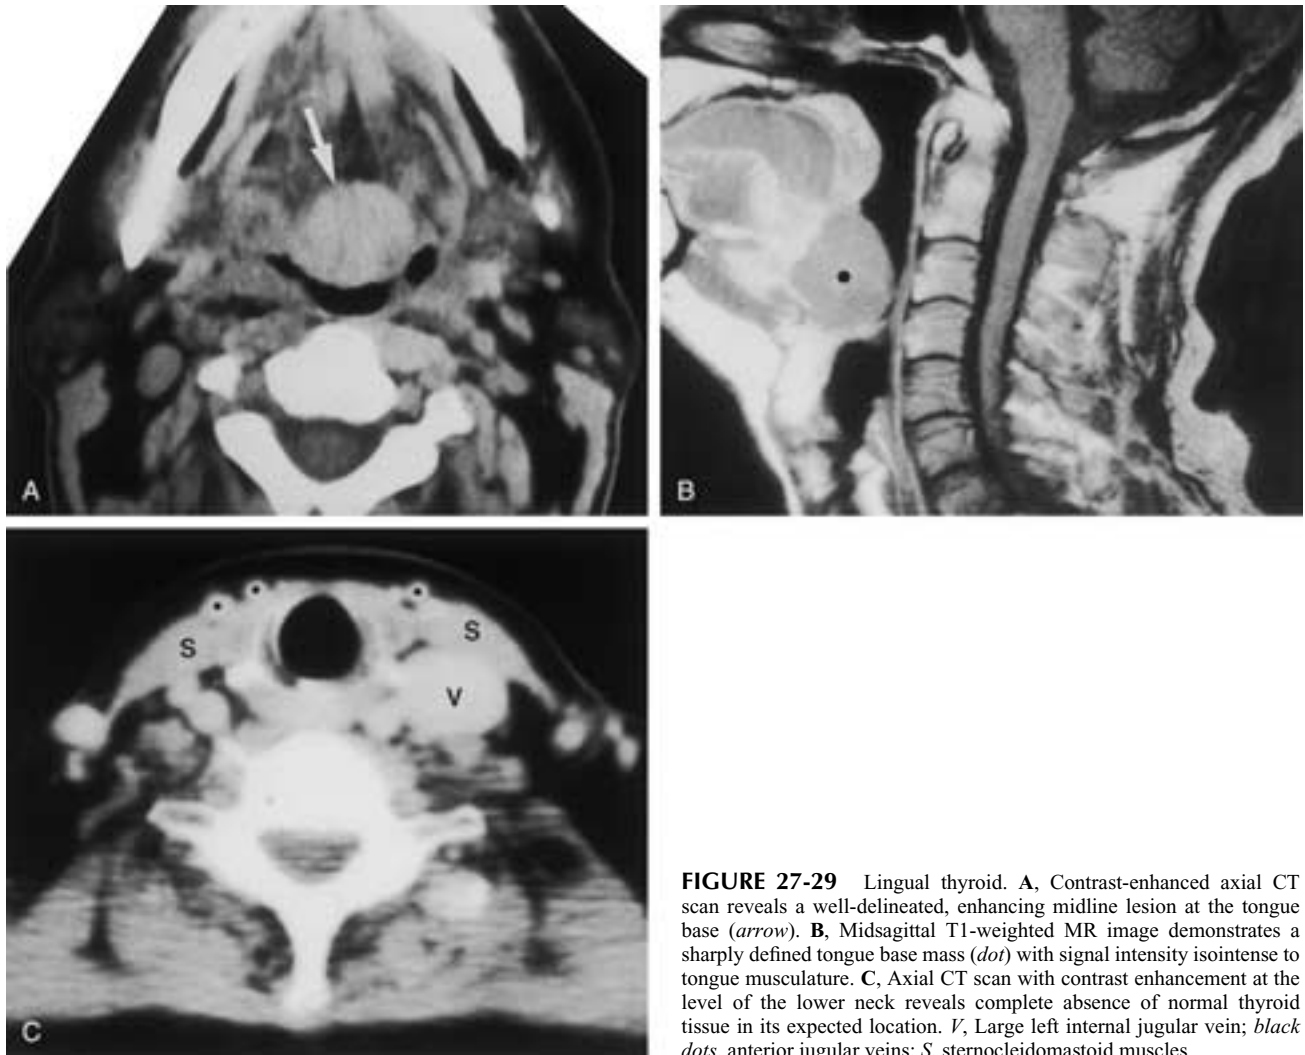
Lingual thyroid. A, Contrast-enhanced axial CT scan reveals a well-delineated, enhancing midline lesion at the tongue base (*arrow*). B, Midsagittal T1-weighted MR image demonstrates a sharply defined tongue base mass (*dot*) with signal intensity isointense to tongue musculature. C, Axial CT scan with contrast enhancement at the level of the lower neck reveals complete absence of normal thyroid tissue in its expected location. *V*, Large left internal jugular vein; *black dots*, anterior jugular veins; *S*, sternocleidomastoid muscles.
